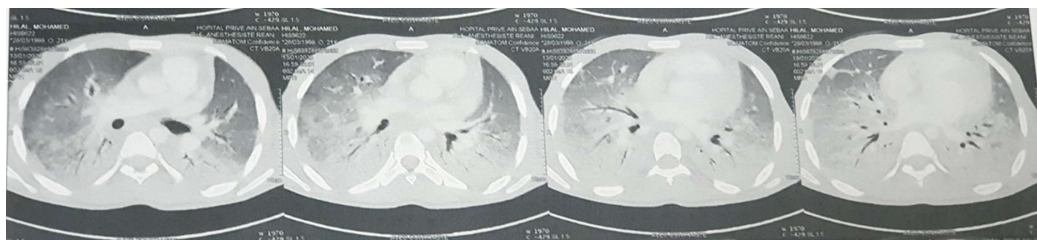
Chest CT Scan on Day 7 of Treatment.
